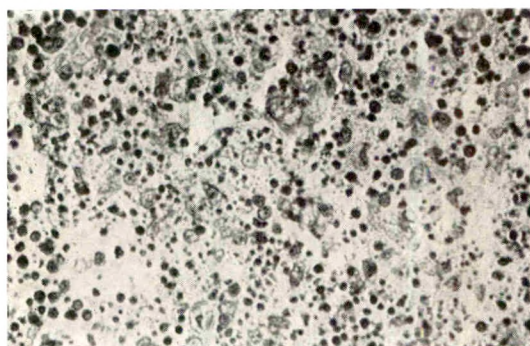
Lymph node six hours after exposure to a larger roentgen dose (1 S.U.D.), showing decomposition of the gland.
